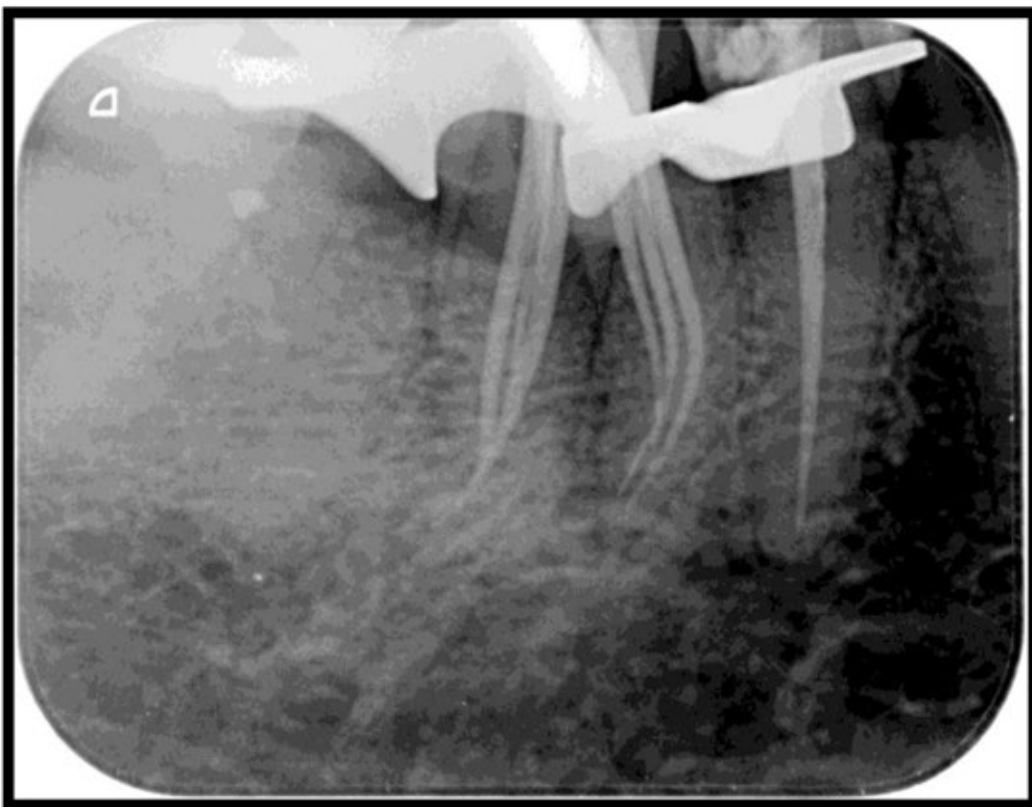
Master cone radiograph
